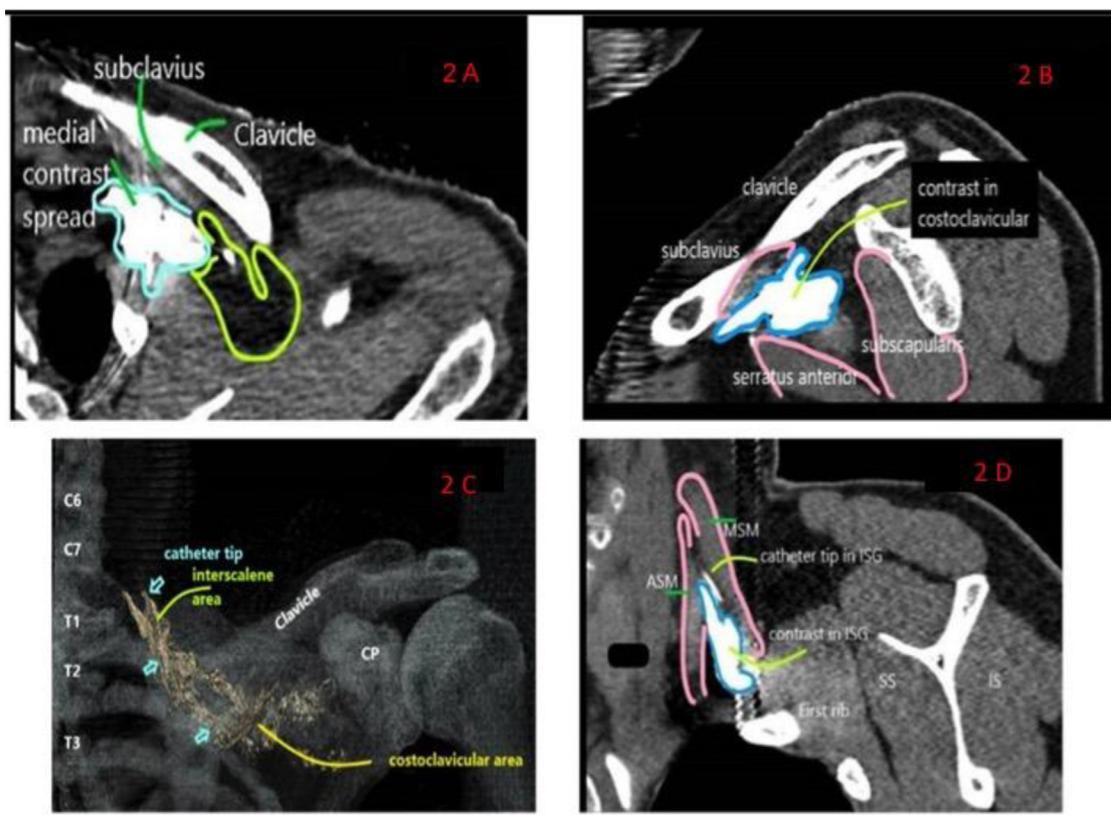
A, axial view of contrast collection below the subclavius with a more medial contrast spread. B, sagittal view of contrast collection in CCS below the subclavius muscle. C, volume rendering CT technique of radiocontrast injection delineates the spread from CCS to the interscalene area delineating the cervical roots. CP, coracoid process. D, coronal view of contrast translocation in the posterior interscalene area between ASM and MSM. ASM, anterior scalene muscle; MSM, middle scalene muscle; SS, subscapularis; IS, infraspinatus; ESM, erector spinae muscle.
